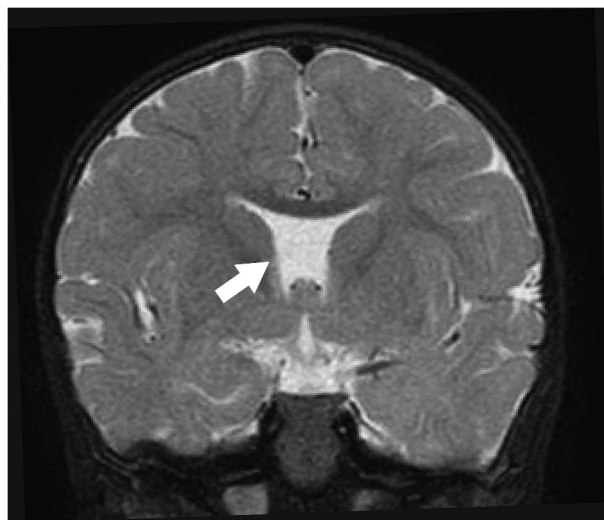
Coronal MRI of a patient (Number 4) with ONH and a brain abnormality (agenesis of the septum pellucidum, white arrow) without general manifestations since the neonatal or infantile period.
